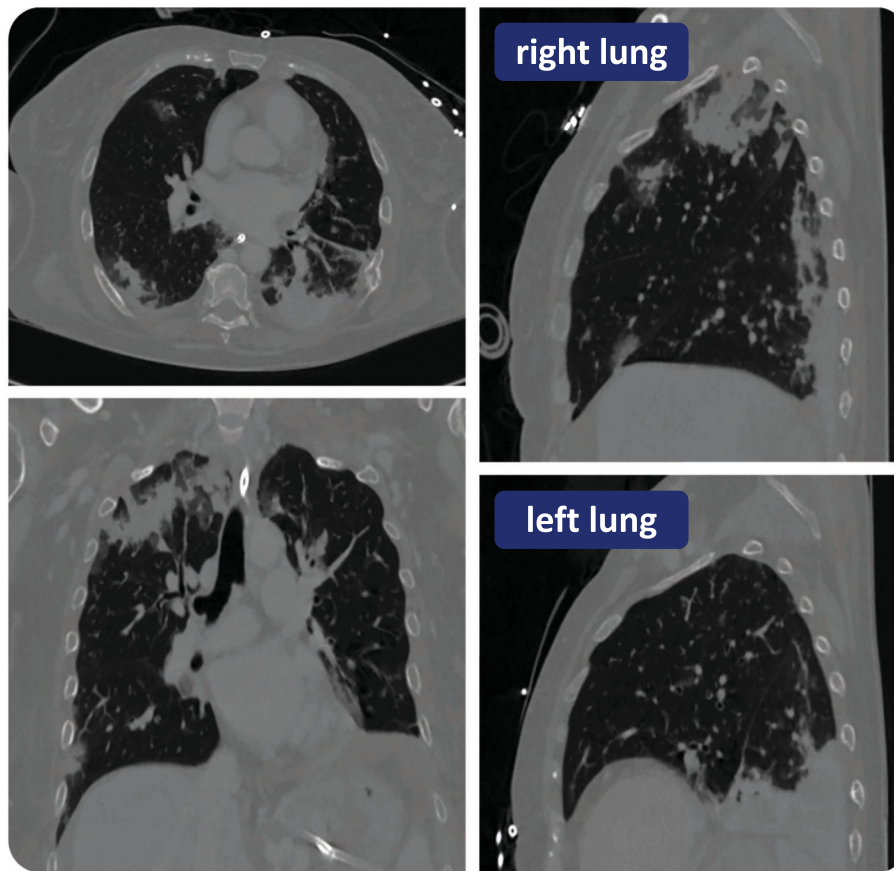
CT scan of the patient in axial, coronal and sagittal (right and left lung) view exhibiting heterogeneous lung regions.
